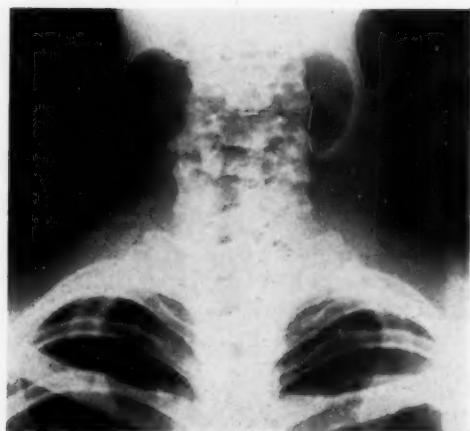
X-ray bilateral laryngoceles, anterior posterior view. Courtesy of Dr. Dudley C. Babb.
